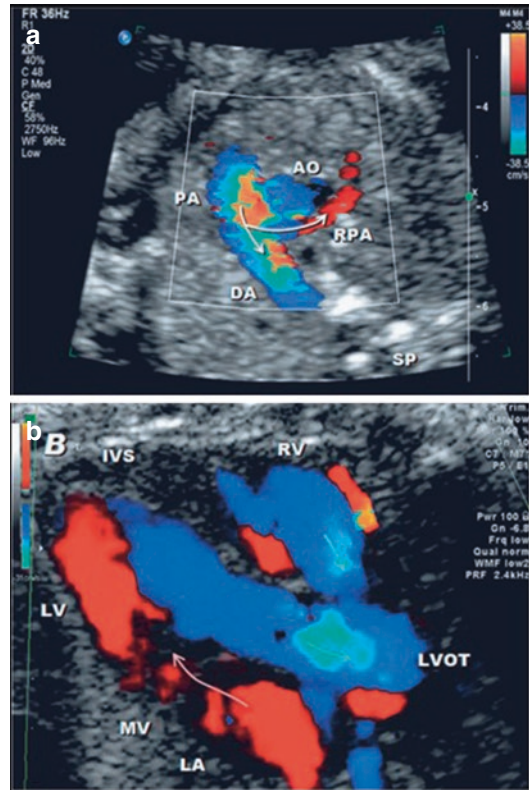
(a, b) Color Doppler echocardiogram of the ventricular outflow tracts. The upper panel: Right ventricular outflow tract is shown in the aortic short-axis plane of the fetal heart. It is noted aliasing in the outflow tracts. The lower panel: Left ventricular outflow is shown in the oblique long-axis view of the fetal heart. The lighter color at the beginning of the aorta is indicative of higher velocity. The arrows depict flow direction AO aorta, IVS interventricular septum, DA ductus arteriosus, LV left ventricle, RV right ventricle, LVOT left ventricular outflow tract, MV mitral valve, PA pulmonary artery, RPA right pulmonary artery, SP fetal spine
